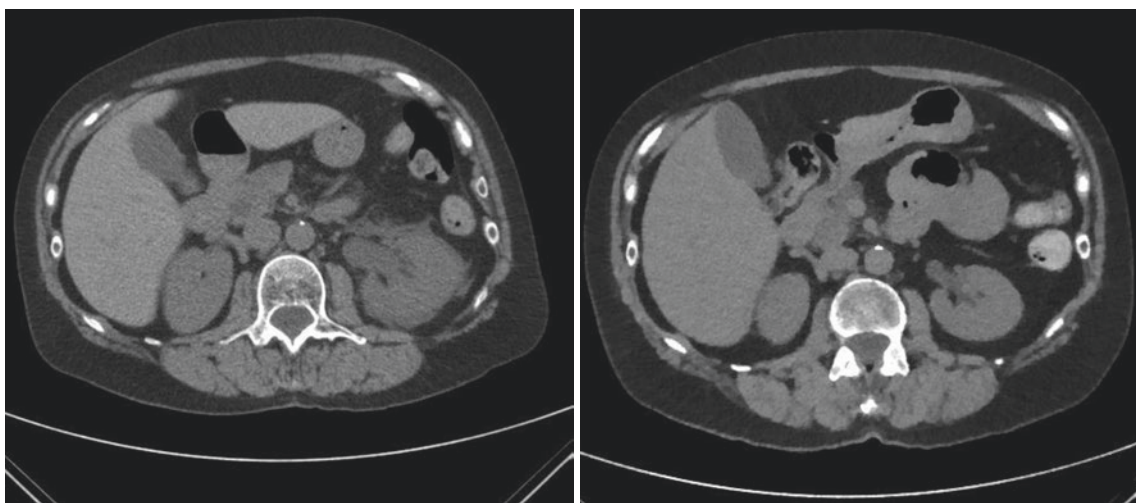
Non-contrast CT of the abdomen showing collecting system dilation with perinephric stranding in the panel on the left. On the right, CT shows resolution following relief of obstruction
